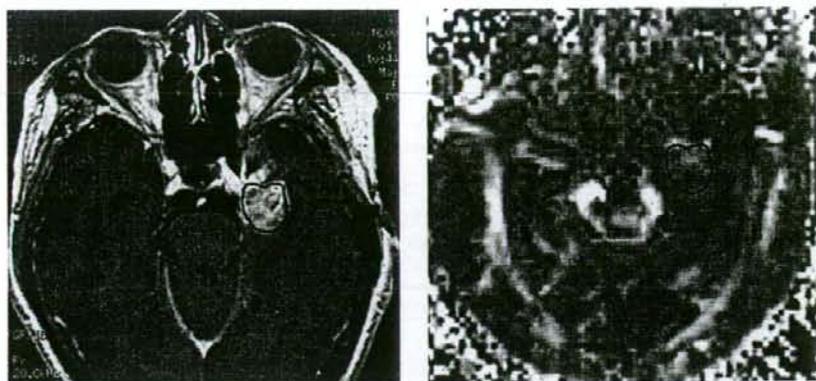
Left: T1-weighted magnetic resonance (MR) image with contrast medium showing the region of interest (ROI) in the solid portion of the lesion. Right: fractional anisotropy map showing the outline of the ROI traced automatically.
